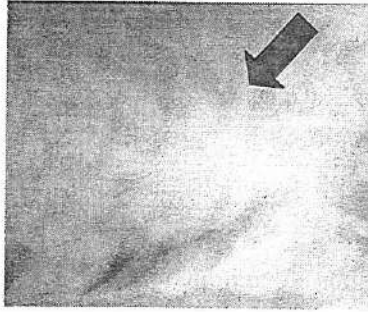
The chest roentgenogram (right lateral decubitus) showed pleural effusion on the right hemithorax
